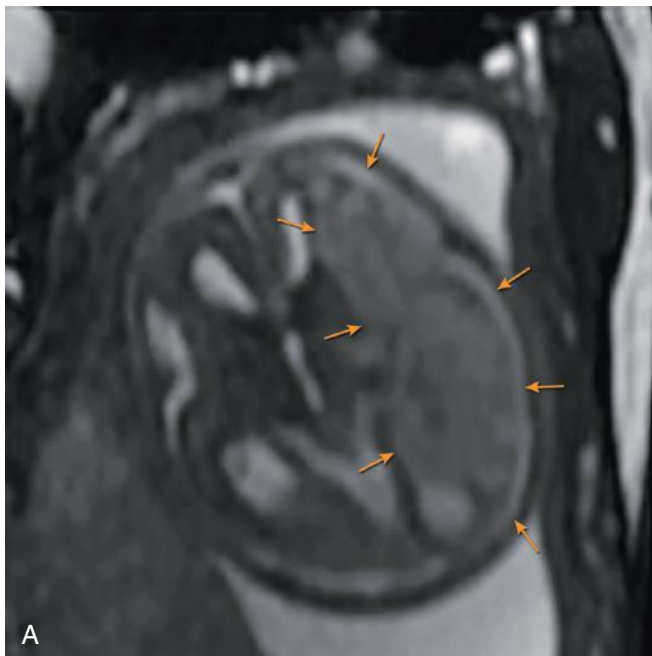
A and B, Large intracranial hemorrhage at 21 weeks' gestation in a patient with cytomegalovirus infection. Axial balanced steady-state image (A) and T1-weighted imaging (B) demonstrate large hematoma (*arrows*) compressing the lateral ventricle.
